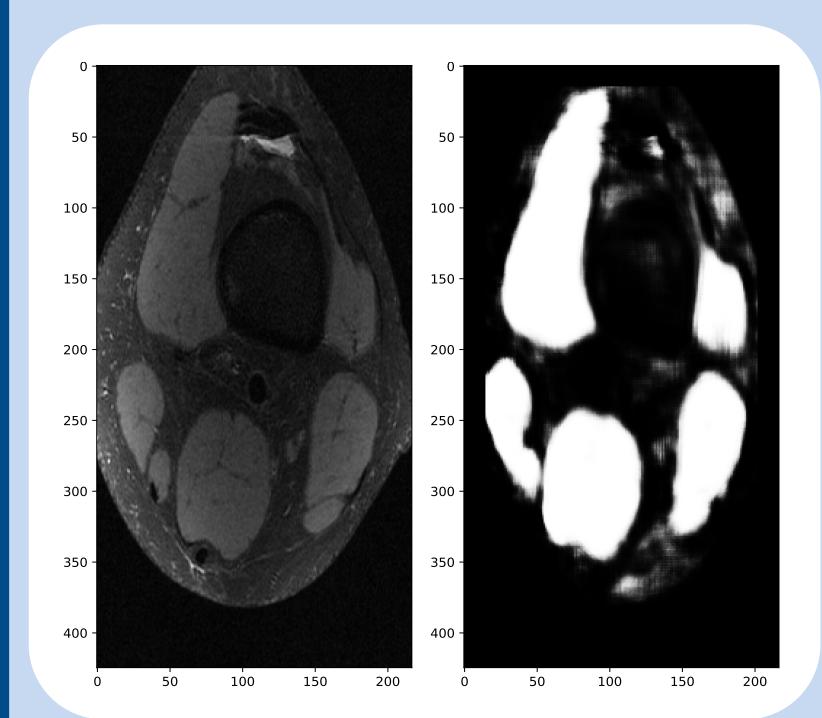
The 3D CNN that was used for segmenting the muscles in knee MRI data.
